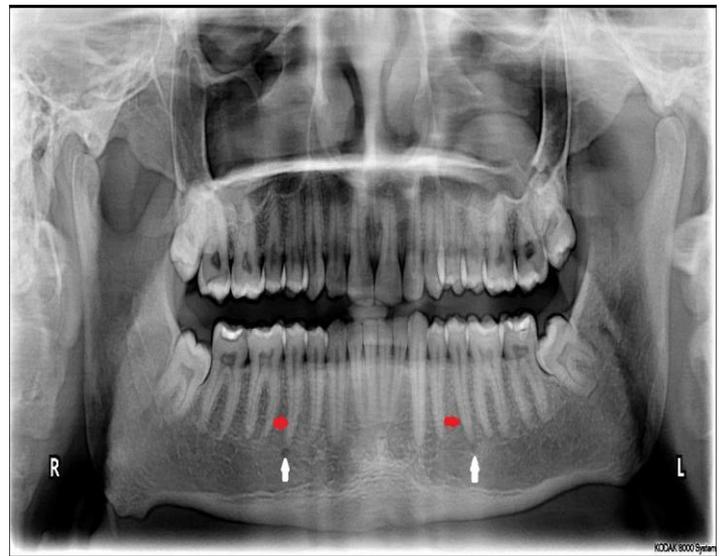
Panoramic radiograph shows horizontal positioning of the mental foramen (white arrow) is in line with second premolar (red arrow) on both right and left side indicating bilateral symmetry.
